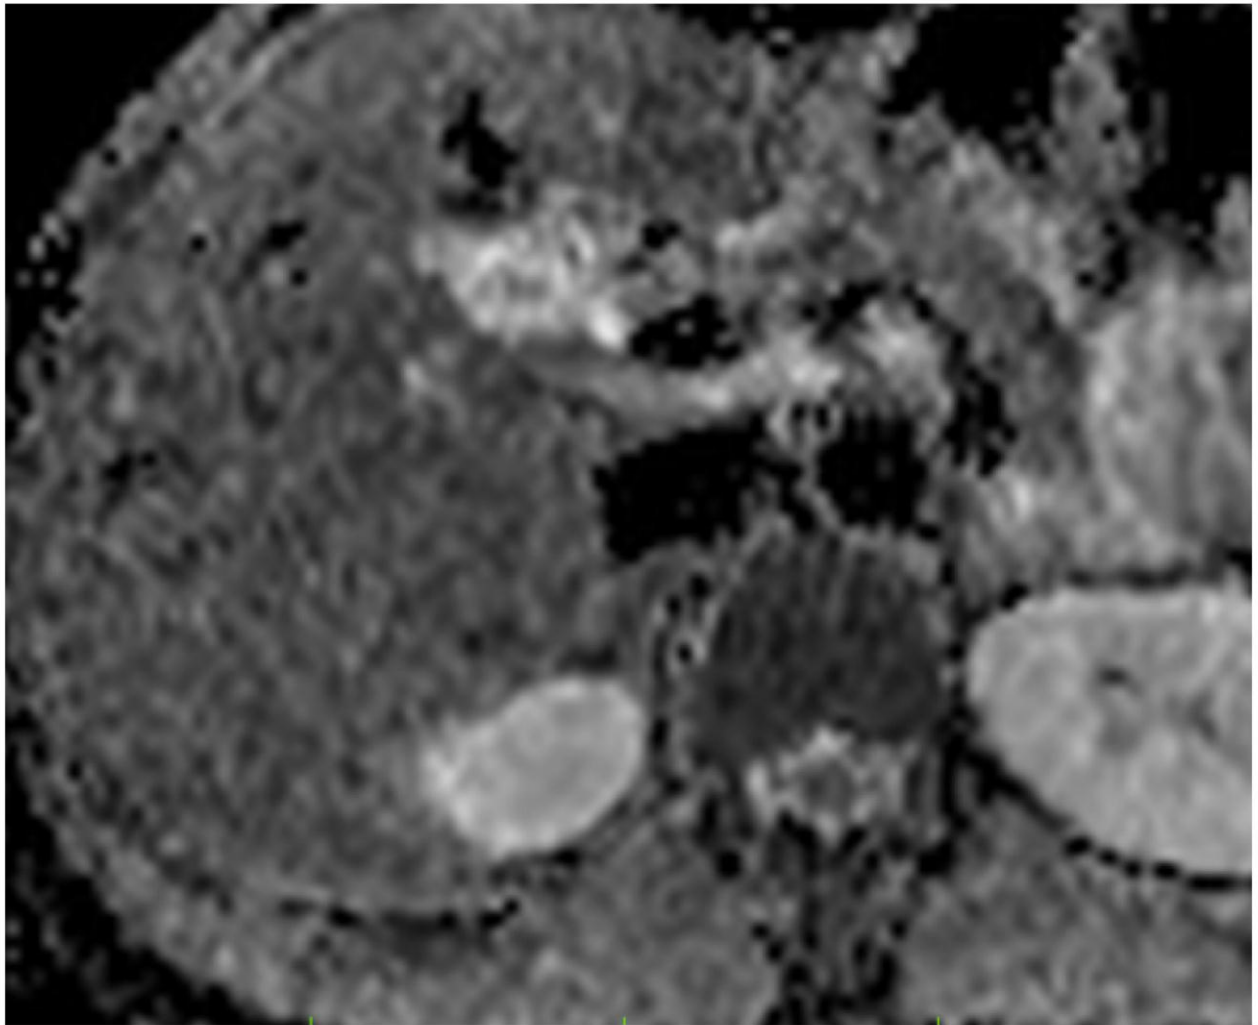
DW MRI. HA shows isointense signal at the ADC maps.
